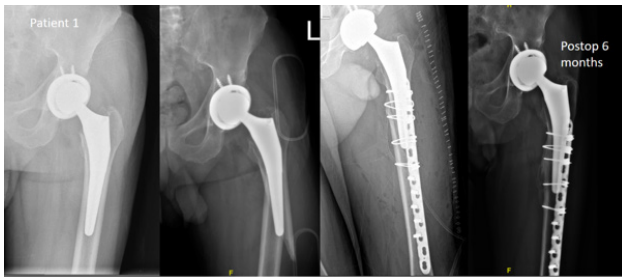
A 65-year-old male patient underwent total hip arthroplasty for primary coxarthrosis. He had a Vancouver type B1 periprosthetic fracture after a fall 2 months after the operation. Cable-plate fixation application to the patient and the radiograph showing the union after 6 months.
